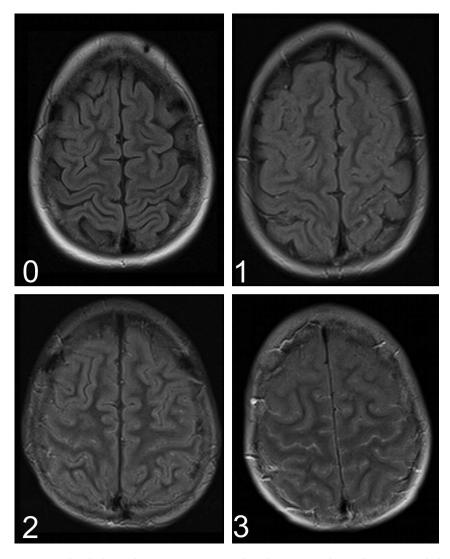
Visual scale for grading SSI in supraventricular sulci: 0 = complete nulling, 1 = stippled hyperintensity, 2 = stippled with areas of confluent hyperintensity, 3 = confluent hyperintensity in sulci. The same grading scale was applied to precontrast and postcontrast FLAIR images.
